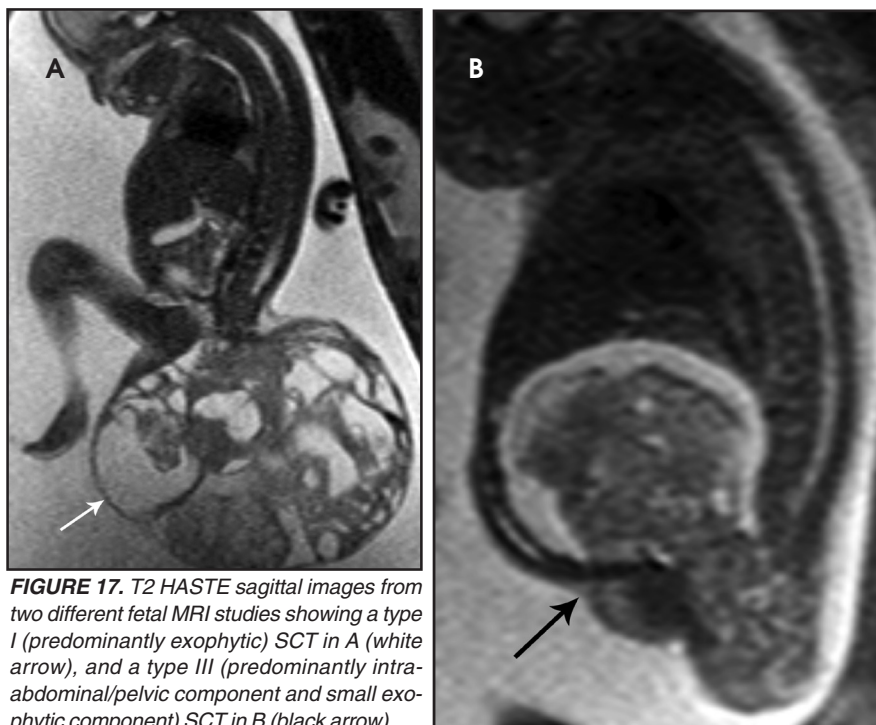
T2 HASTE sagittal images from two different fetal MRI studies showing a type I (predominantly exophytic) SCT in A (white arrow), and a type III (predominantly intra-abdominal/pelvic component and small exophytic component) SCT in B (black arrow).
